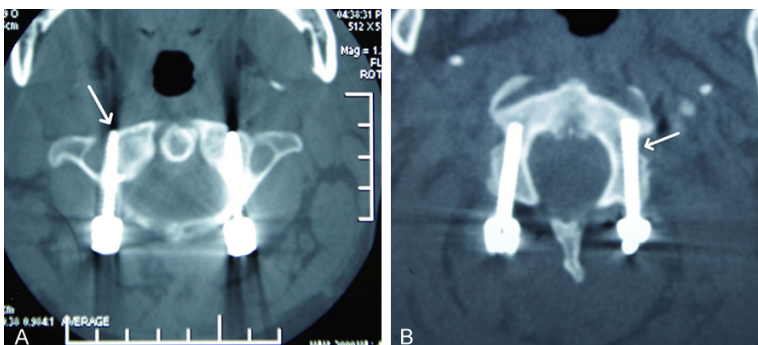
Postoperative CT scans showed the position of the C1 lateral mass and C2 pedicle screws in two different patients. The right C1 lateral mass screw (B) and the left C2 pedicle screw (A) breached out of the cortical wall.
